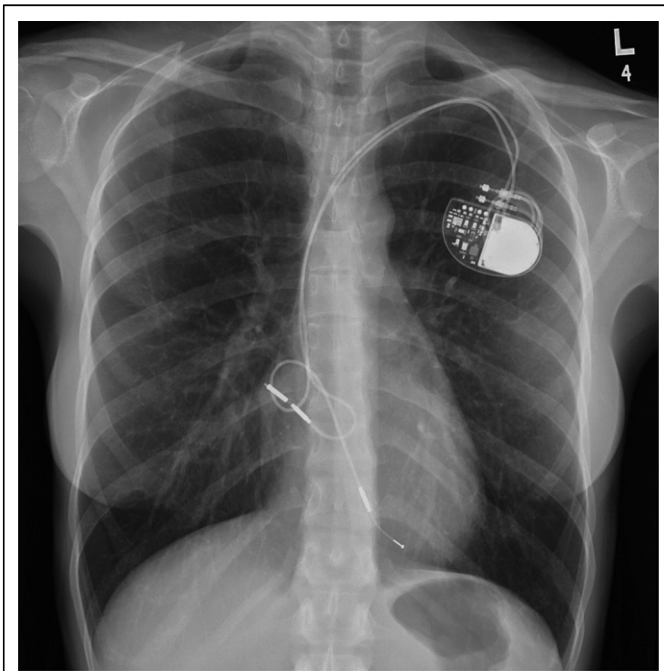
Chest X-ray showing the loop of the atrial pacemaker lead as it crosses down and returns back to the right atrium.
